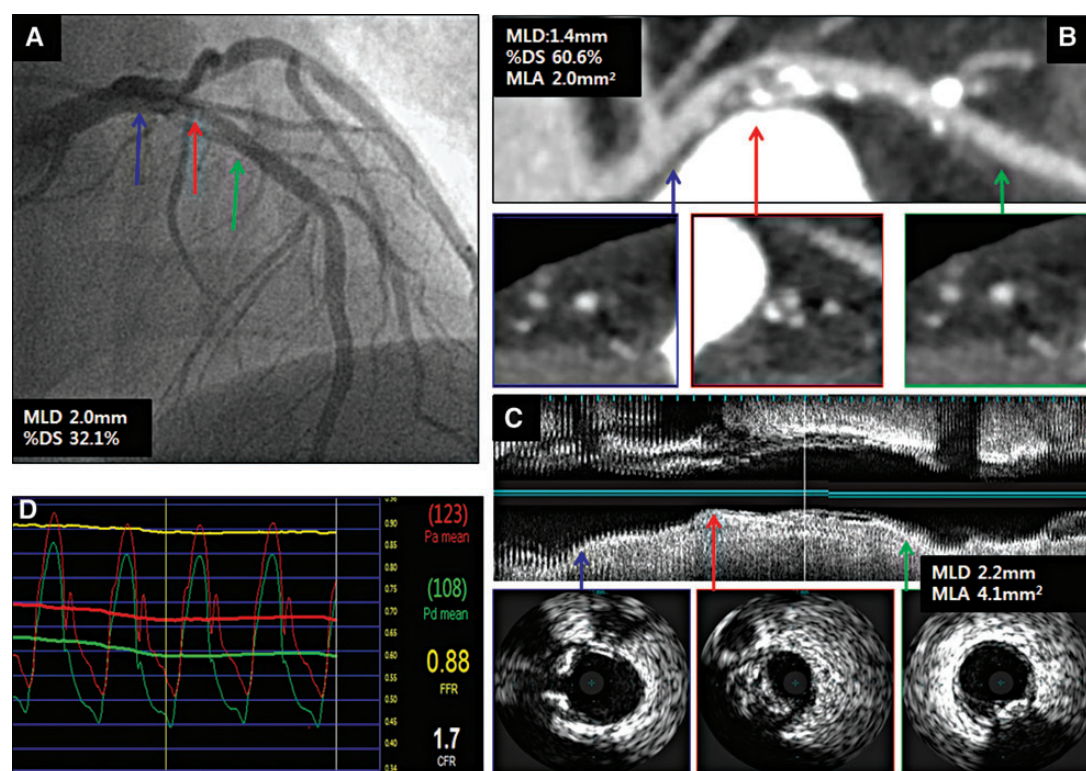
A representative case demonstrating ICA (A), CCTA (B), IVUS (C), and FFR (D) assessment for the stenosis located in the proximal left anterior descending coronary artery. Blue arrow indicates proximal reference; green arrow, distal reference; and red arrow, minimal lumen site. ICA, invasive coronary angiography; CCTA, coronary computed tomographic angiography; IVUS, intravascular ultrasound; FFR, fractional flow reserve; MLD, minimal lumen diameter; %DS, per cent diameter stenosis; MLA, minimal lumen area.
